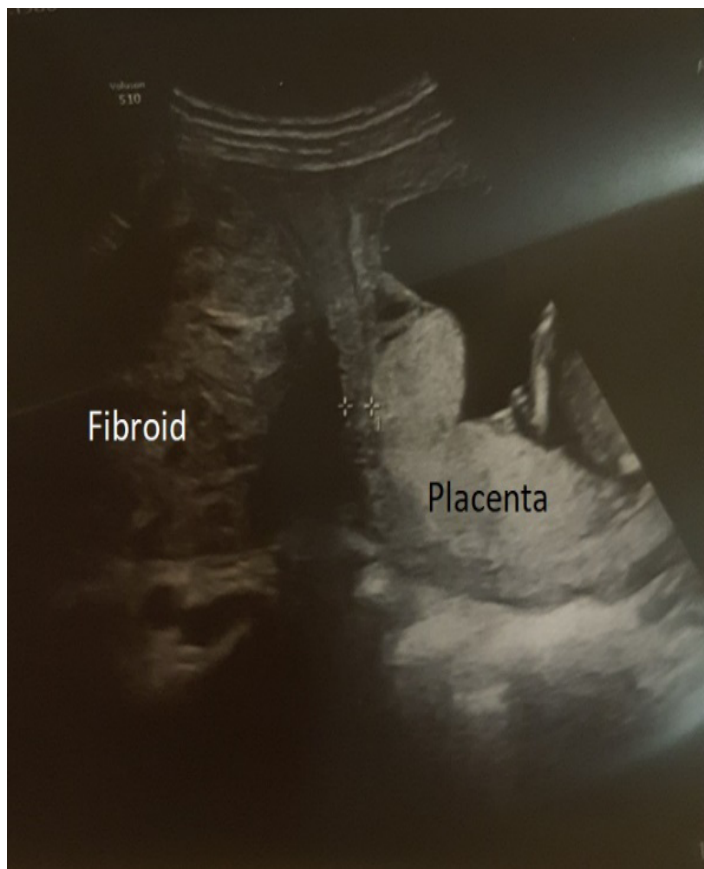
Ultrasonography image: Distance between fibroid and placenta.
